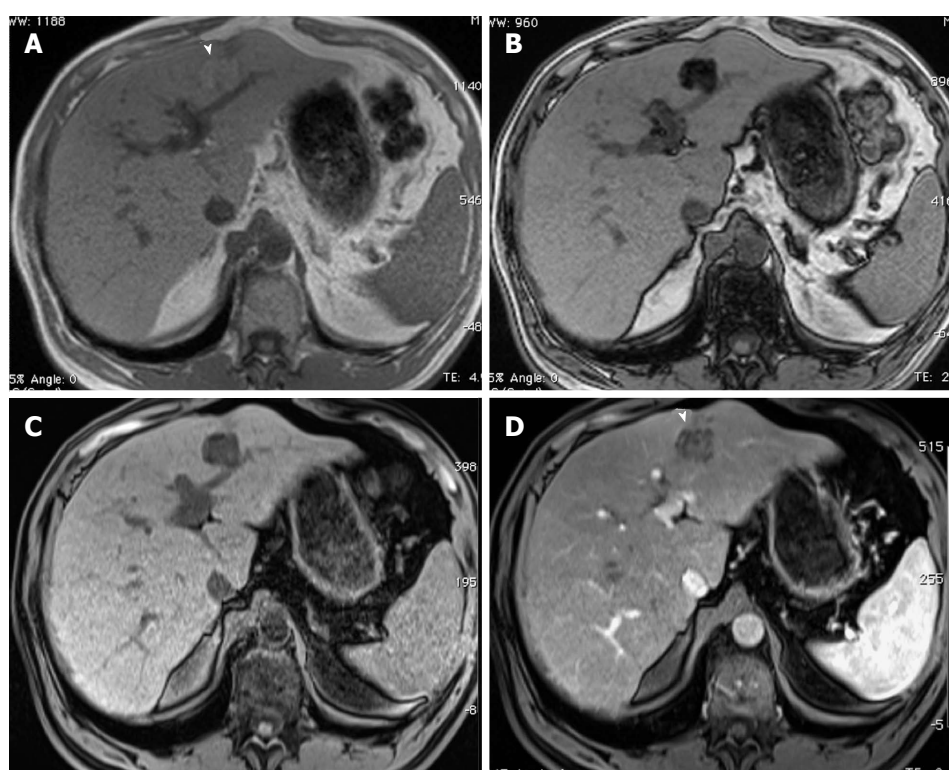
Large, fat-containing hepatocellular carcinoma. In-phase (A) and opposed-phase (B) GRE T1 weighted images. Pre- (C) and post-contrast fat-suppressed 3D-GRE T1-weighted images during late hepatic arterial phase (D). There is a prominent left hepatic nodule, which demonstrates minimally increased intrinsic T1 signal on the in-phase images (arrowhead, A) and low signal intensity on the opposed-phase (B) and pre-contrast images (C), indicating the presence of fat. The lesion demonstrates heterogeneous mildly increased arterial enhancement (arrowhead, D) in keeping with a fat-containing HCC. HCC: Hepatocellular carcinoma; GRE: Gradient recalled echo.
